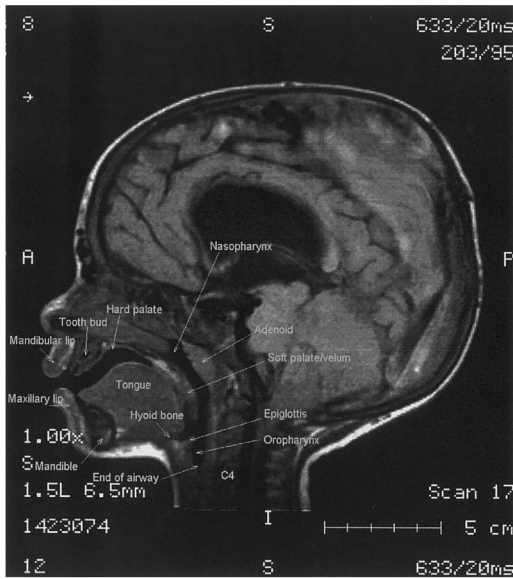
Labeled structures: midsagittal MRI slice of a 1 year, 1 month old male subject.
